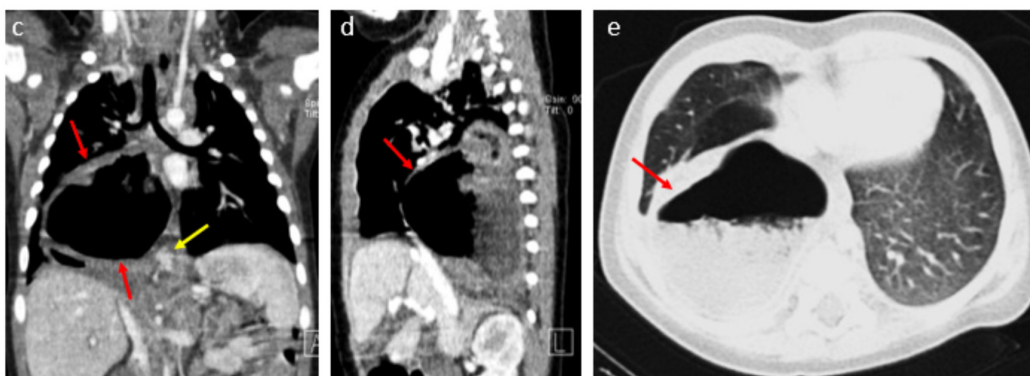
c-e. In contrast-enhanced thorax computed tomography examination, coronal (c) and sagittal (d) reformatted, axial plane lung window (e) images show the entire stomach (red arrows) and a part of the pancreas (yellow arrow) is herniated into the right hemithorax
